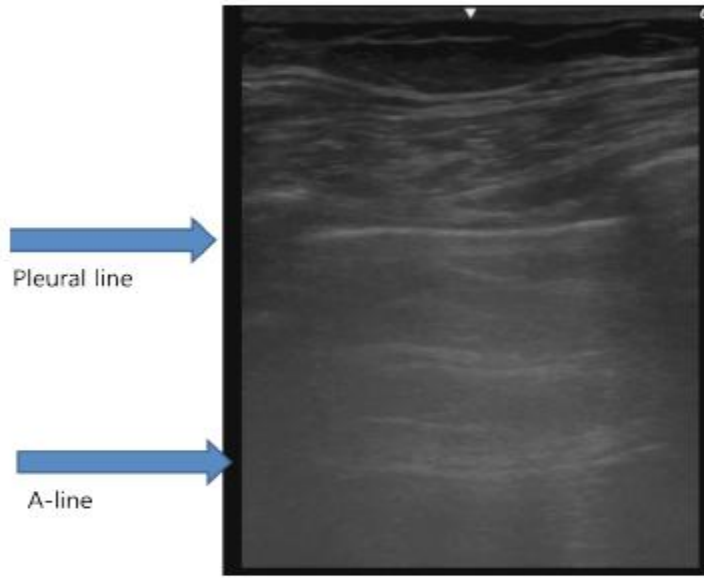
Normal findings of lung ultrasound: A-lines are horizontal hyperechoic lines parallel to the pleural line and are basic artifacts of a normally aerated lung.
